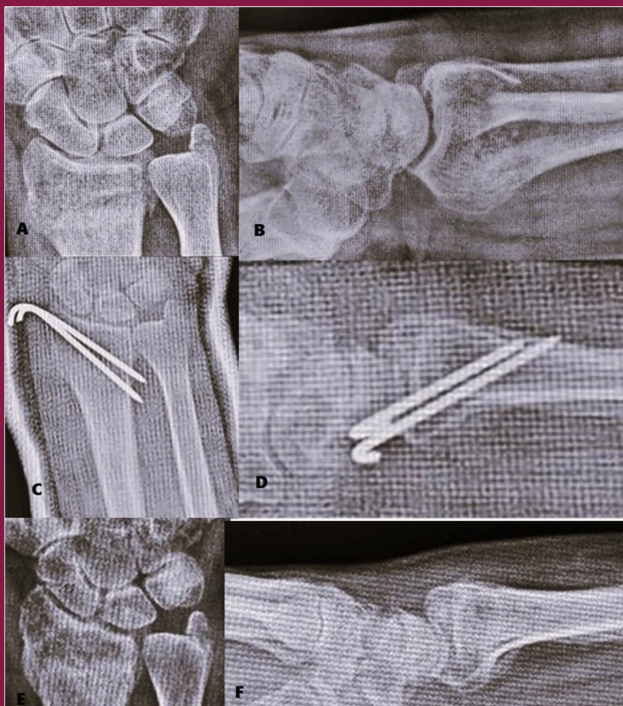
A 62-year-old female patient. A/B: Preoperative, C/D: After 2 weeks of operation, E/F: After 8 weeks of operation Pa and Lateral wrist X-ray
